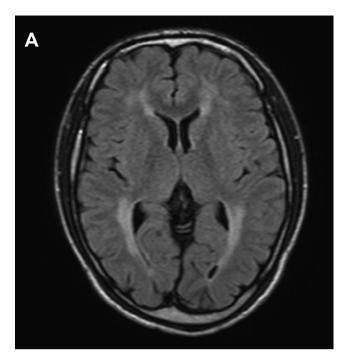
Brain MRI at diagnosis of the patient. Axial fluid-attenuated inversion recovery imaging revealed diffuse leukoencephalopathy with preservation of U-fibers.
